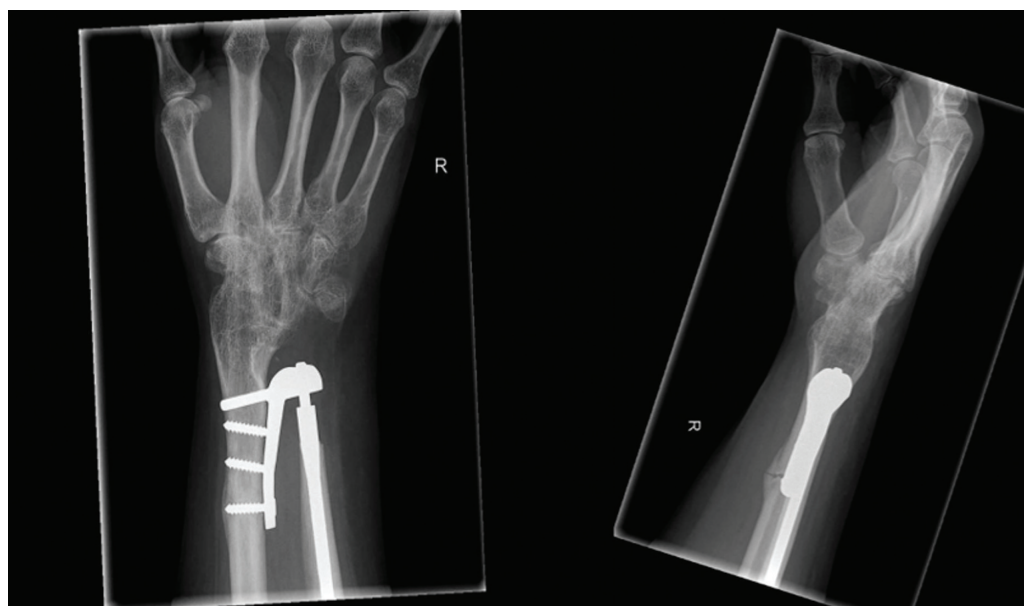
Anteroposterior and lateral X-rays of Case 2, 3 months after the placement of the Aptis implant. Note, the periprosthetic fracture at the level of the proximal screw.
